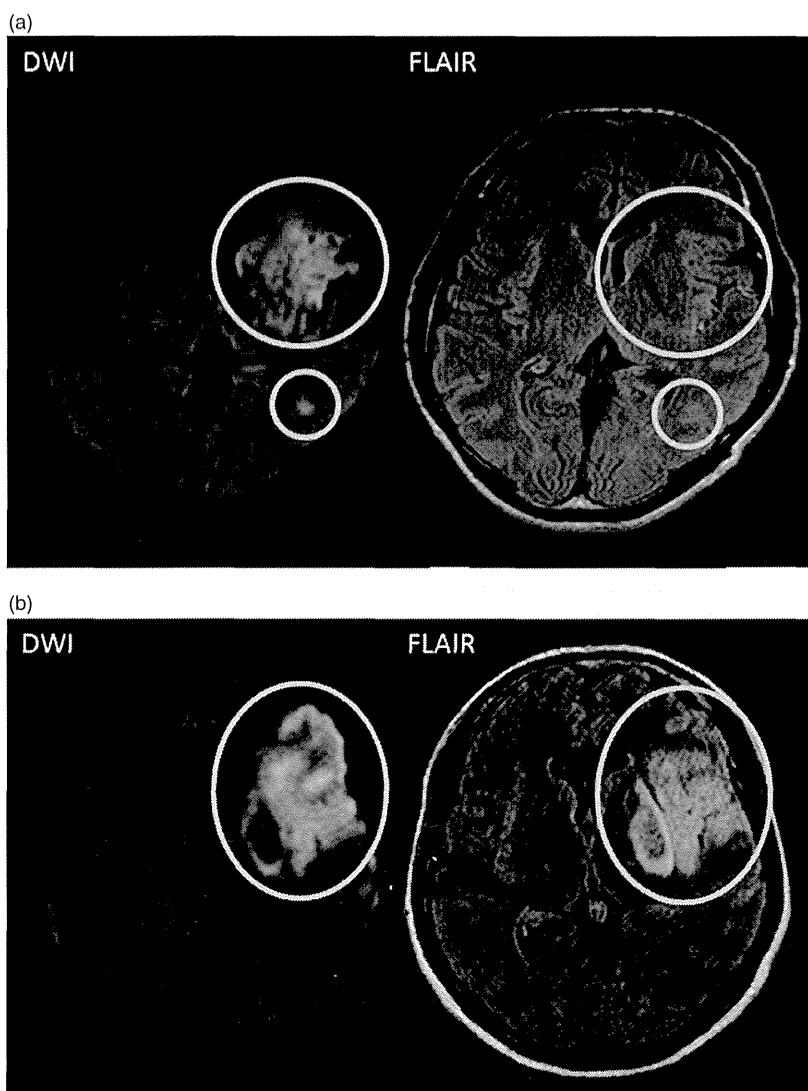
Examples of magnetic resonance imaging (MRI) inclusion and exclusion criteria. (a) A negative fluid-attenuated inversion recovery (FLAIR) pattern shows an acute ischemic lesion clearly visible on diffusion-weighted imaging (DWI), but no marked parenchymal hyperintensity visible on fluid-attenuated inversion recovery (FLAIR) corresponding to the DWI lesion (yellow circles). (b) A positive FLAIR pattern shows an acute ischemic lesion clearly visible on DWI and clear parenchymal hyperintensity on FLAIR corresponding to the acute DWI lesion (yellow circle).
